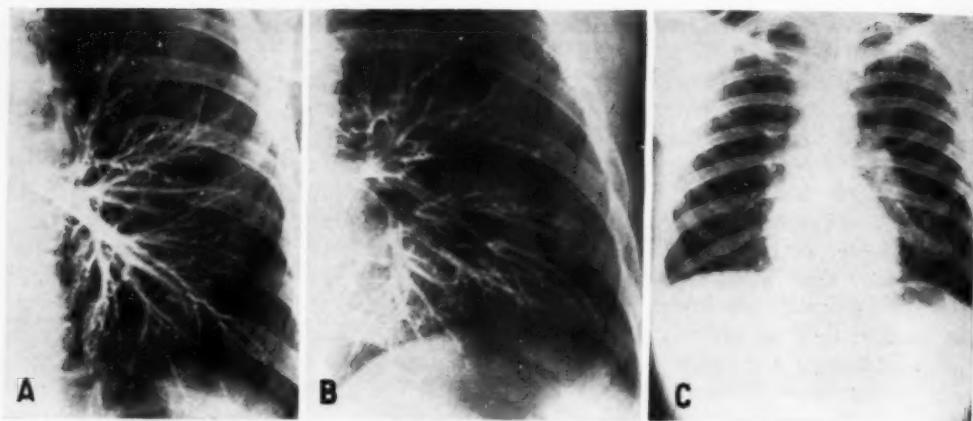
A. Normal left bronchogram with aqueous Dionosil. B. Close-up view to show double-contrast effect. C. Roentgenogram taken twenty-four hours later to show disappearance of opaque medium.
